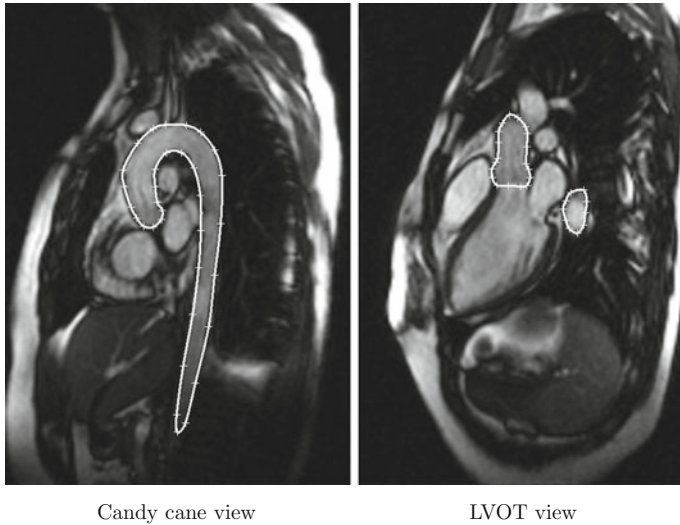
MR image data with manual tracing of the aorta [38, ©2009 Elsevier]
